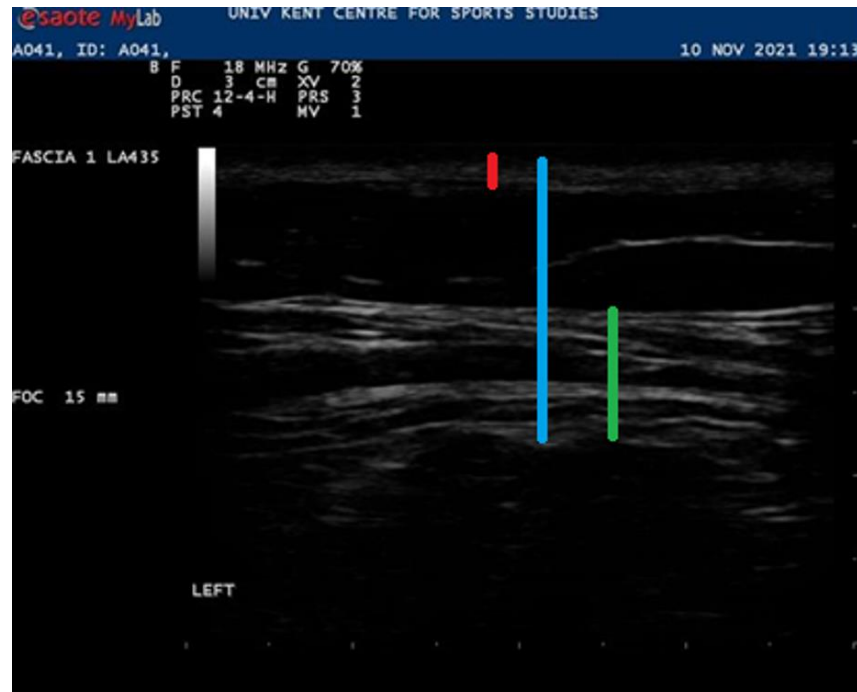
Ultrasound image depicting the three thoracolumbar fascia zones.
